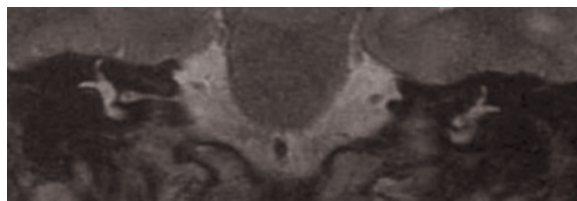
Coronal T2-weighted MR image. Malformations of both internal auditory canals: stenosis on the right and absence on the left.
